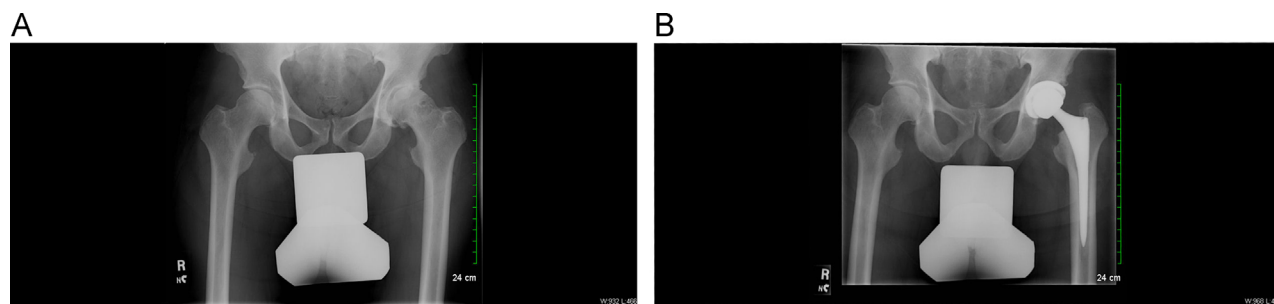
(A) Mesomorph male, 5'11". 209 lb with osteoarthritis, dense bone, and Dorr Type A femur. (B) Post-operative x-ray of the same patient. Due to the dense bone and tight canal, a relatively small stem, with high offset, had a tight fit. Satisfactory limb length and offset restoration.
